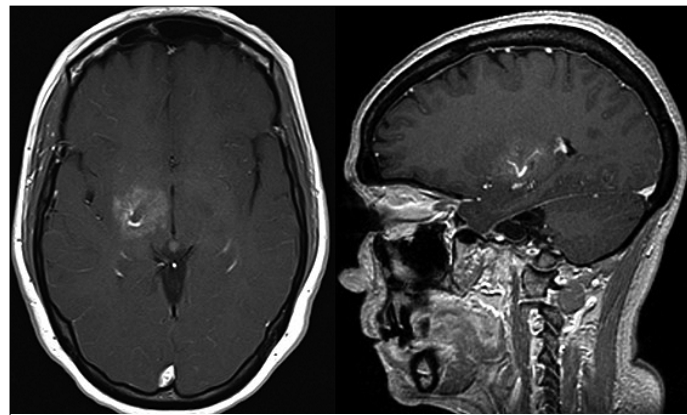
Magnetic Resonance image, in T1 sequence with contrast agent in axial and sagittal view. there is a "brush" pattern with a central vein in the right basal ganglia.
